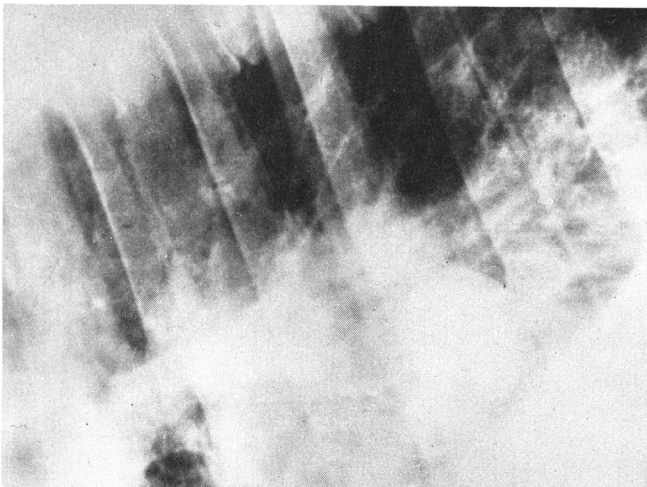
A similar radiograph of Case A taken five days after Fig. 1. There is a similar increase in lung density to Fig. 1, but, in addition, a discrete, spherical opacity (arrows) is apparent immediately ventral to the main caudal lobar bronchus and immediately cranial to the line of the diaphragm. This is an intra-pulmonary hematoma.
